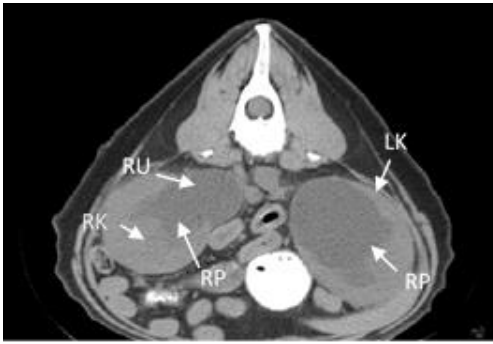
CT image of the right and left kidneys: RK – right kidney, RU – right ureter, LK – left kidney, RP – renal pelvis.
